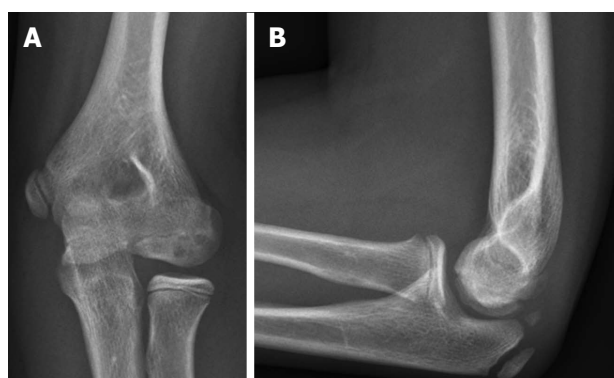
Plain radiography of the elbow showing an osteochondritis dissecans lesion of the capitellum. A: Anteroposterior; B: Lateral.
